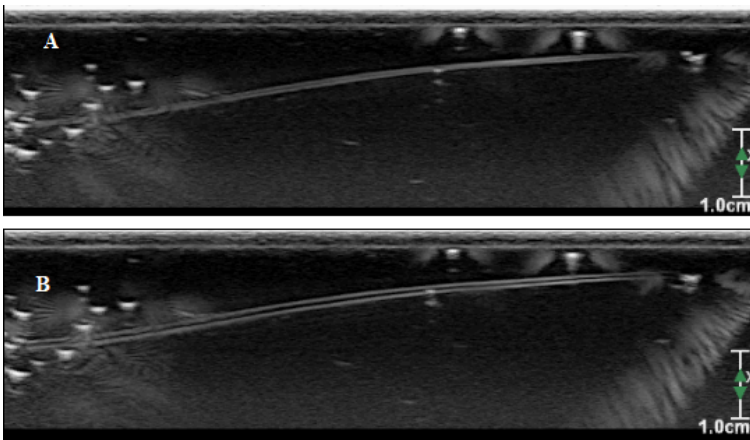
Ultrasound images of a 150 μm in diameter channel. Water was injected by hand in sequences which results in a shape change of the channel. A shows the micro channel during a low water flow compared to the water flow in B.
